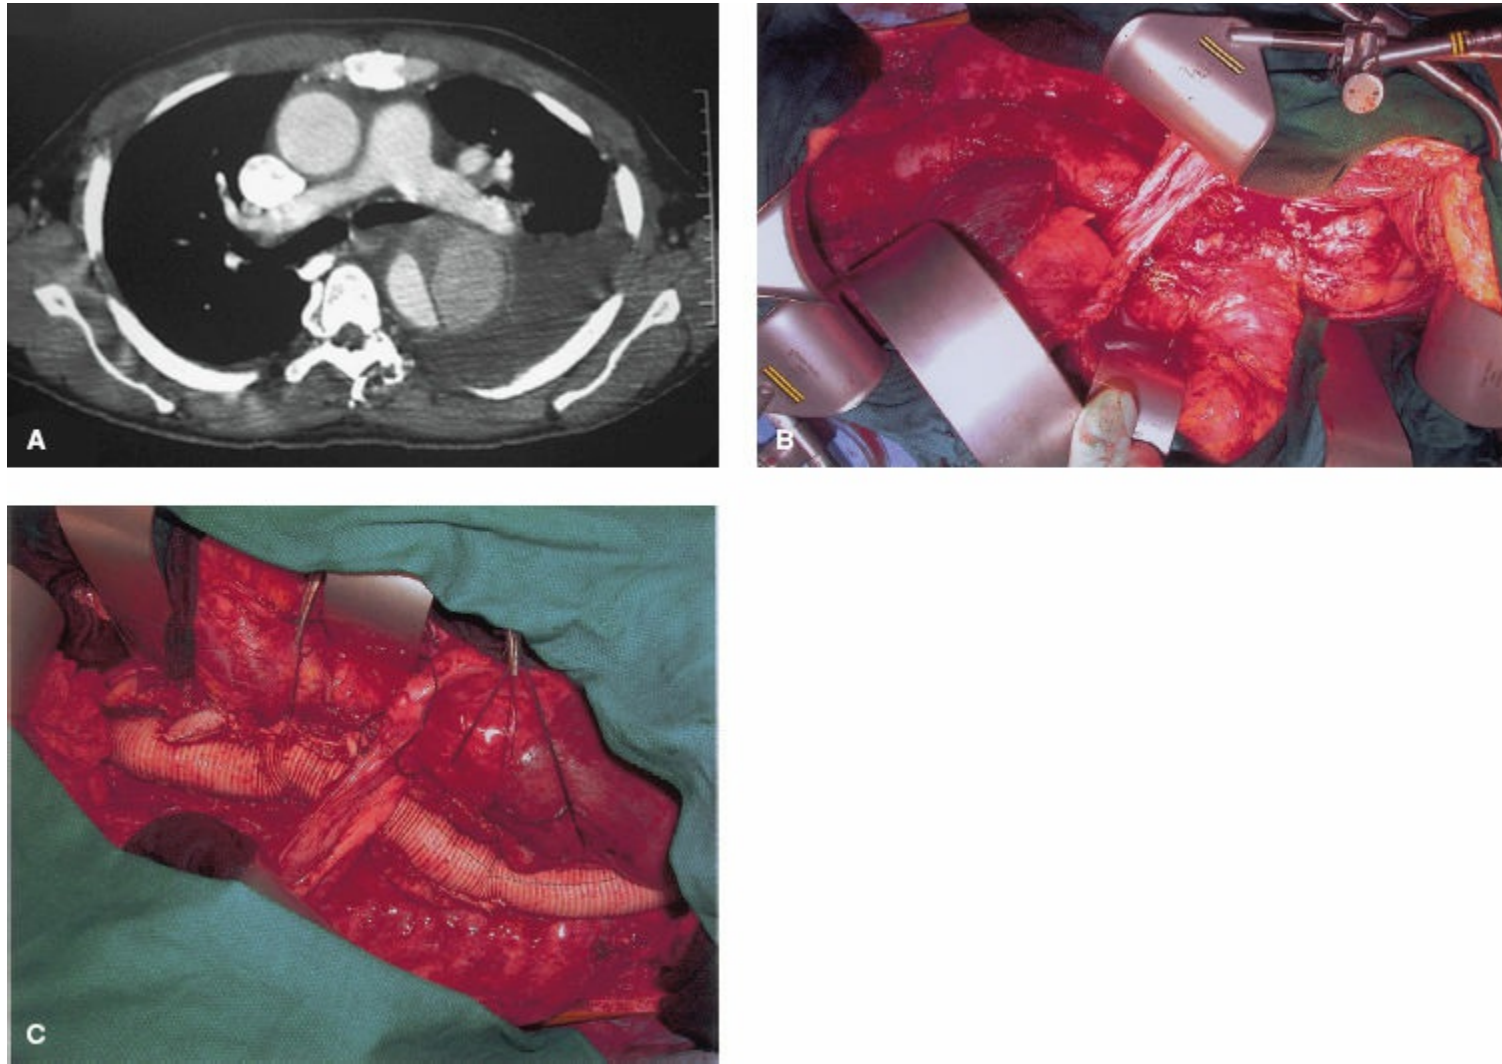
Example of TAAA extent II repair. (A) Preoperative computed tomography showing proximal part of the aneurysm with chronic dissection. Intraoperative photograph of the thoracoabdominal aortic aneurysm before (B) and after (C) graft replacement. The proximal anastomosis was just distal to the left subclavian artery; the patent lower intercostal arteries were reattached; the celiac, superior mesenteric and right renal arteries were reimplanted together; the left renal artery was reimplanted via an interposition bypass graft; and the distal anastomosis was to the aorta just above the bifurcation. The separate left renal artery graft was necessary because it was located far away from the remaining visceral arteries.
